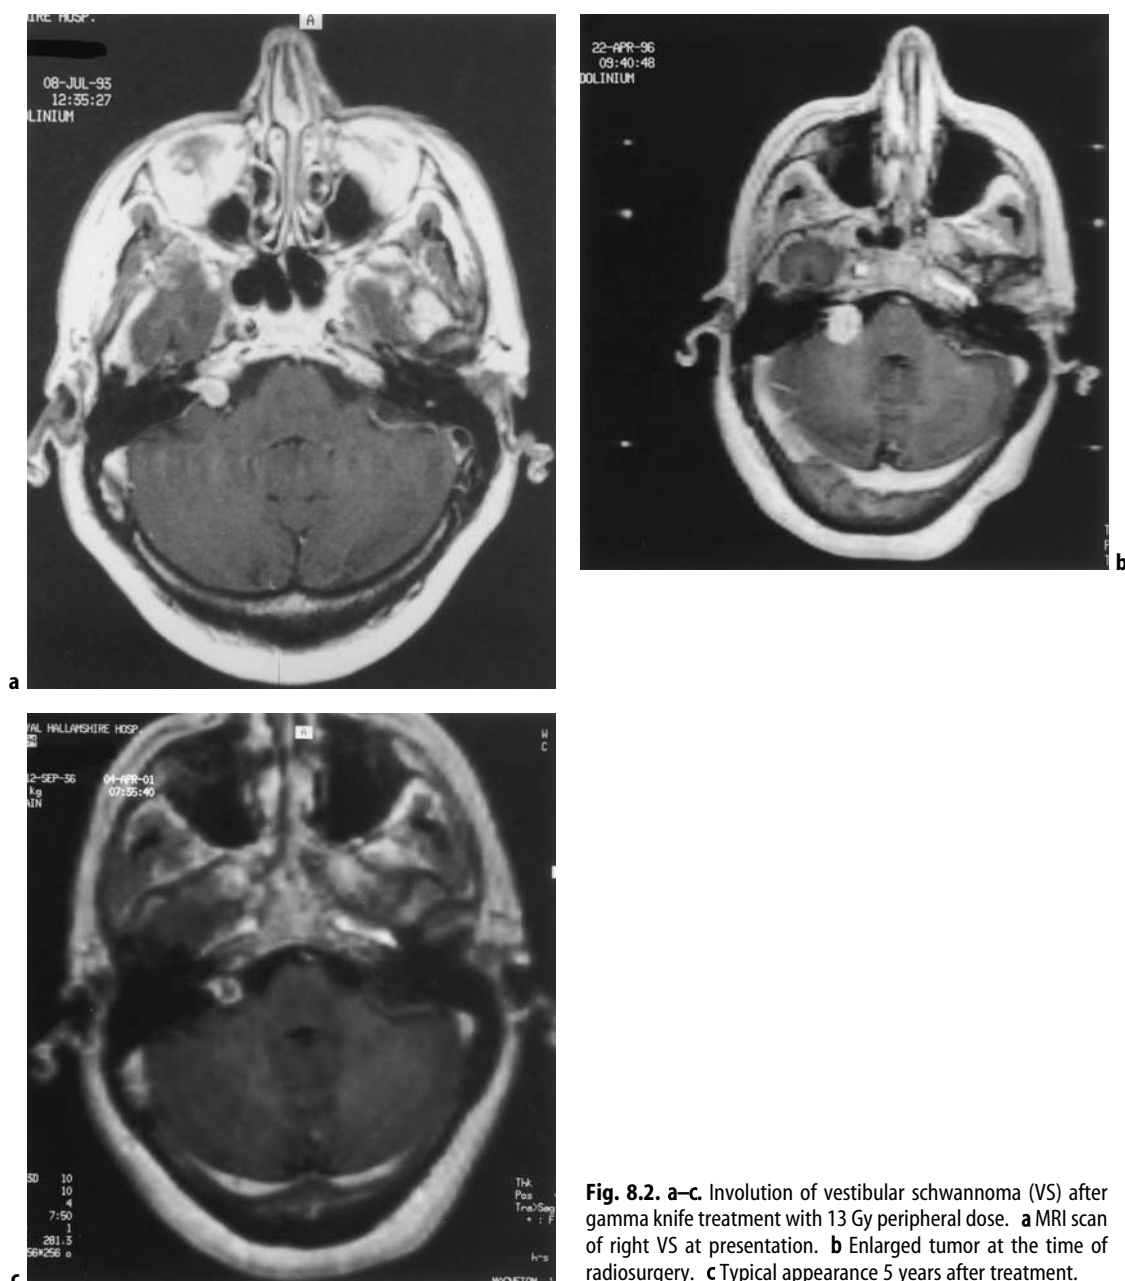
a–c. Involution of vestibular schwannoma (VS) after gamma knife treatment with 13 Gy peripheral dose. a MRI scan of right VS at presentation. b Enlarged tumor at the time of radiosurgery. c Typical appearance 5 years after treatment.
